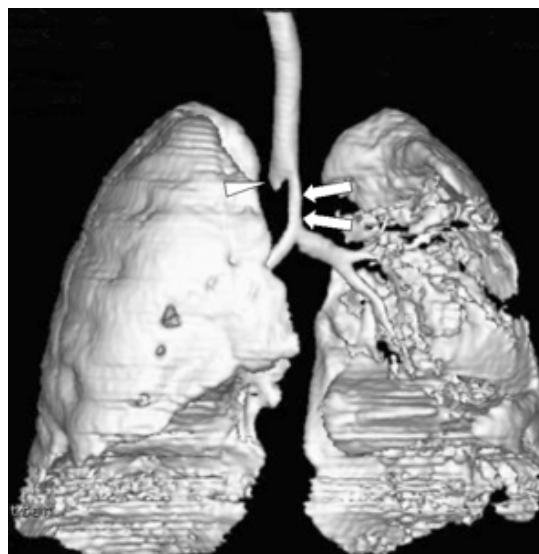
Three-dimensional (3D) reconstruction CT image, anteroposterior view, shows 13-mm segment of severe narrowing (arrows) of the lower trachea from below the tracheal bronchus (arrowhead) to the carina.
